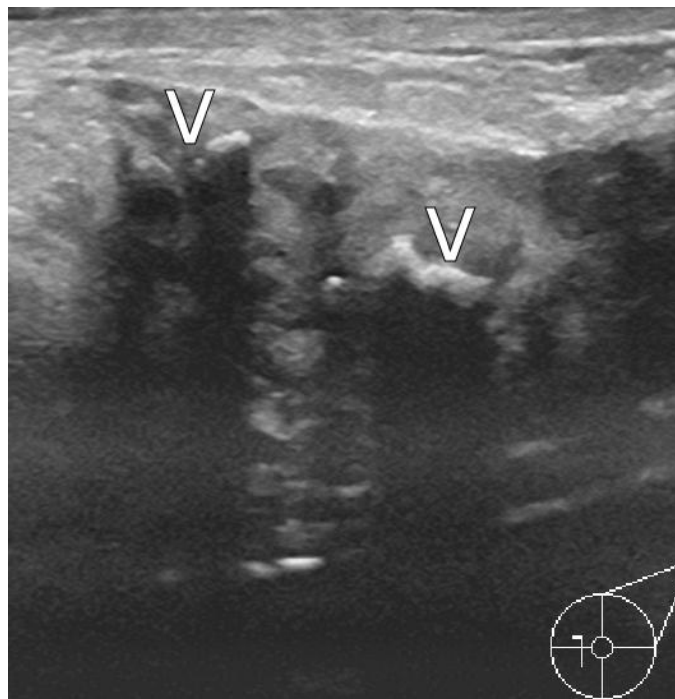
This is a 43 year-old, black female with the discoid variant of SLE who would soon be diagnosed with the rare manifestation of lupus mastitis. Ultrasound of the left breast with a 9 MHz linear transducer in the area of palpable concern upon her initial presentation demonstrates benign coarse, dystrophic calcifications (arrowhead) and no focal mass.
